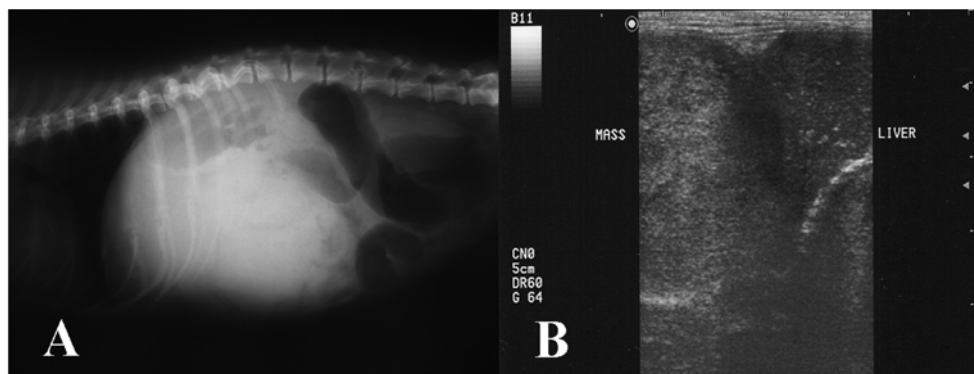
A photograph of lateral radiography. Note severe hepatomegaly with soft tissue density and displaced stomach (A). A photograph of ultrasonography. Note hyperechoic hepatic mass in left lateral hepatic lobe (B).
